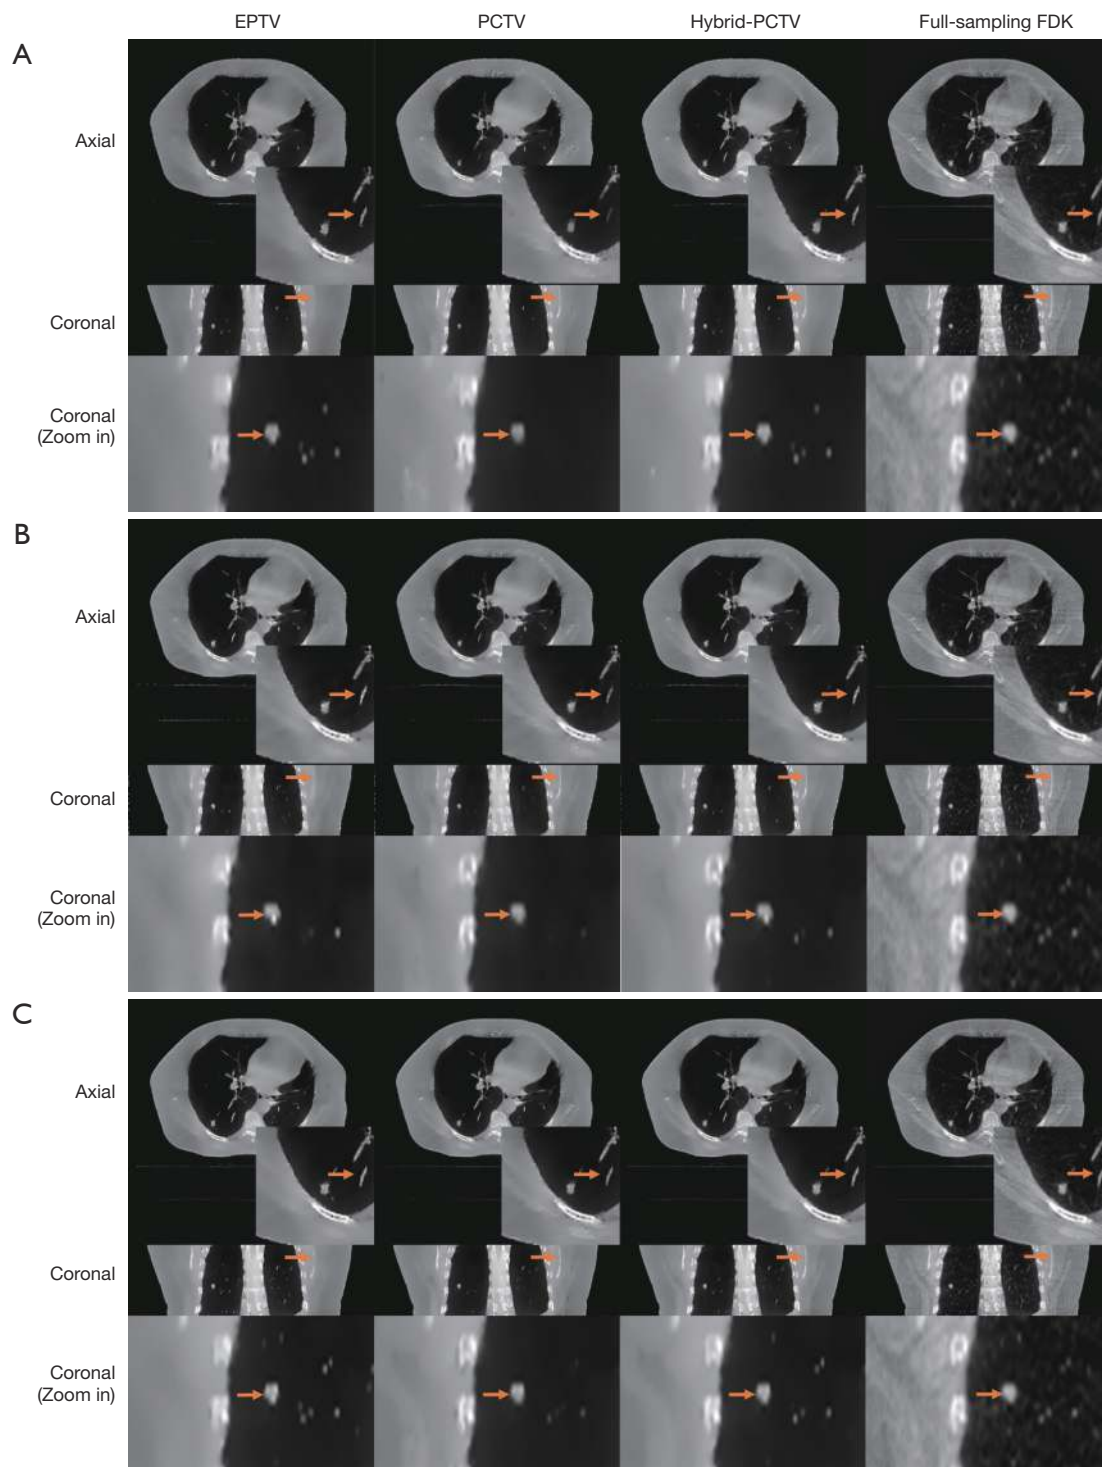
Comparisons of lung CBCT reconstructed via EPTV, PCTV and hybrid-PCTV using (A) 111 projections, (B) 149 projection and (C) 223 projections. Full sampling FDK using 894 half-fan projections are listed at the right column as the reference. The arrows indicate that hybrid-PCTV can enhance the edge sharpness of the tumor, small structures in the lung and bone. CBCT, cone-beam computed tomography; PCTV, prior contour based TV; EPTV, edge preserving TV.
